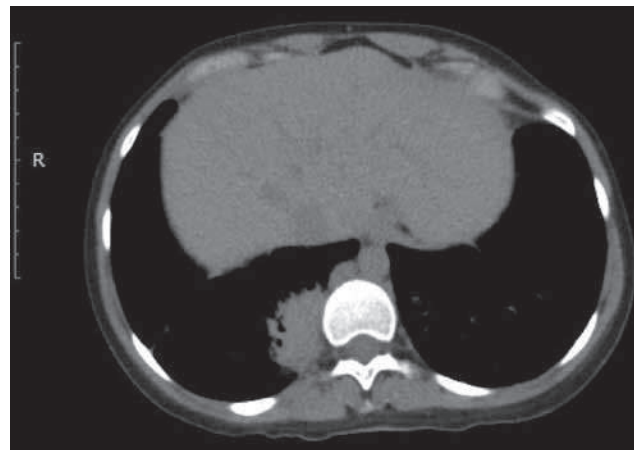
CT reveals solitary pulmonary mass in lower lobe of right lung.
